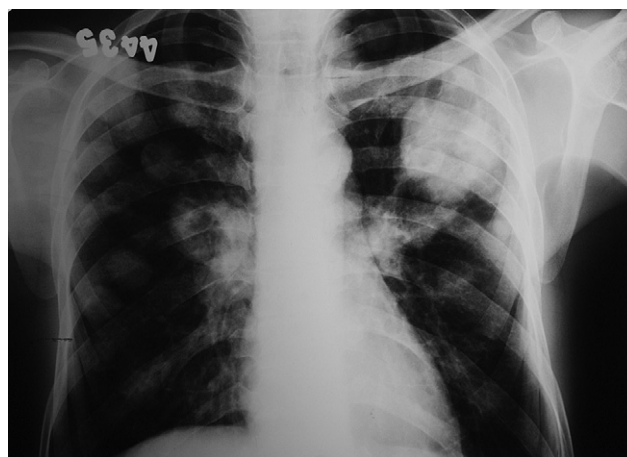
Chest X-ray showing innumerable nodular lesions in both lungs resembling metastasis.
